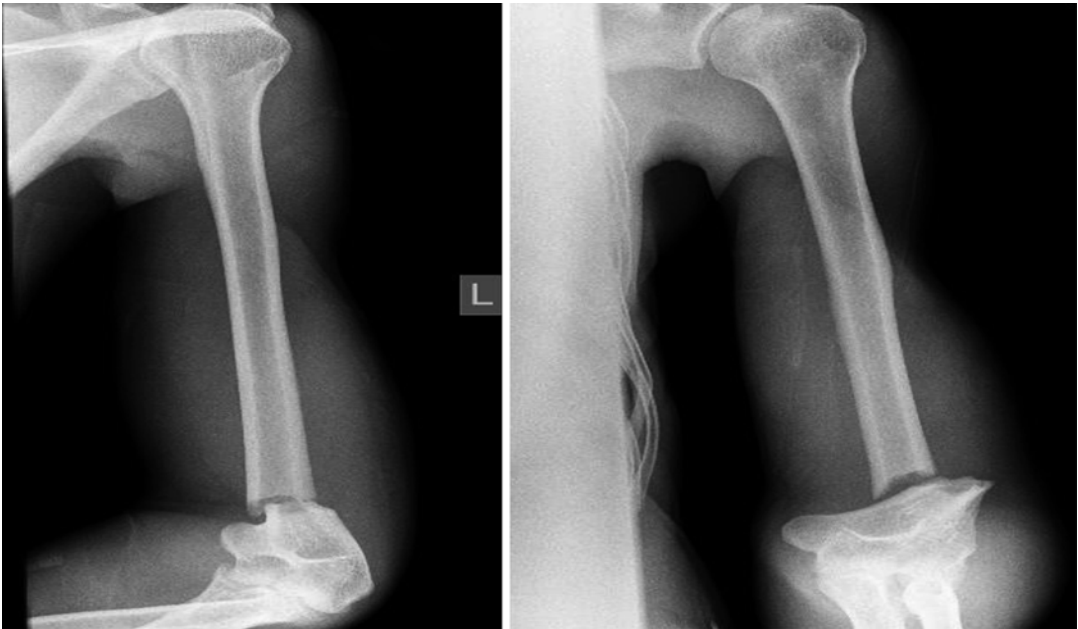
Preoperative X-ray of patient discussed in Case 2
